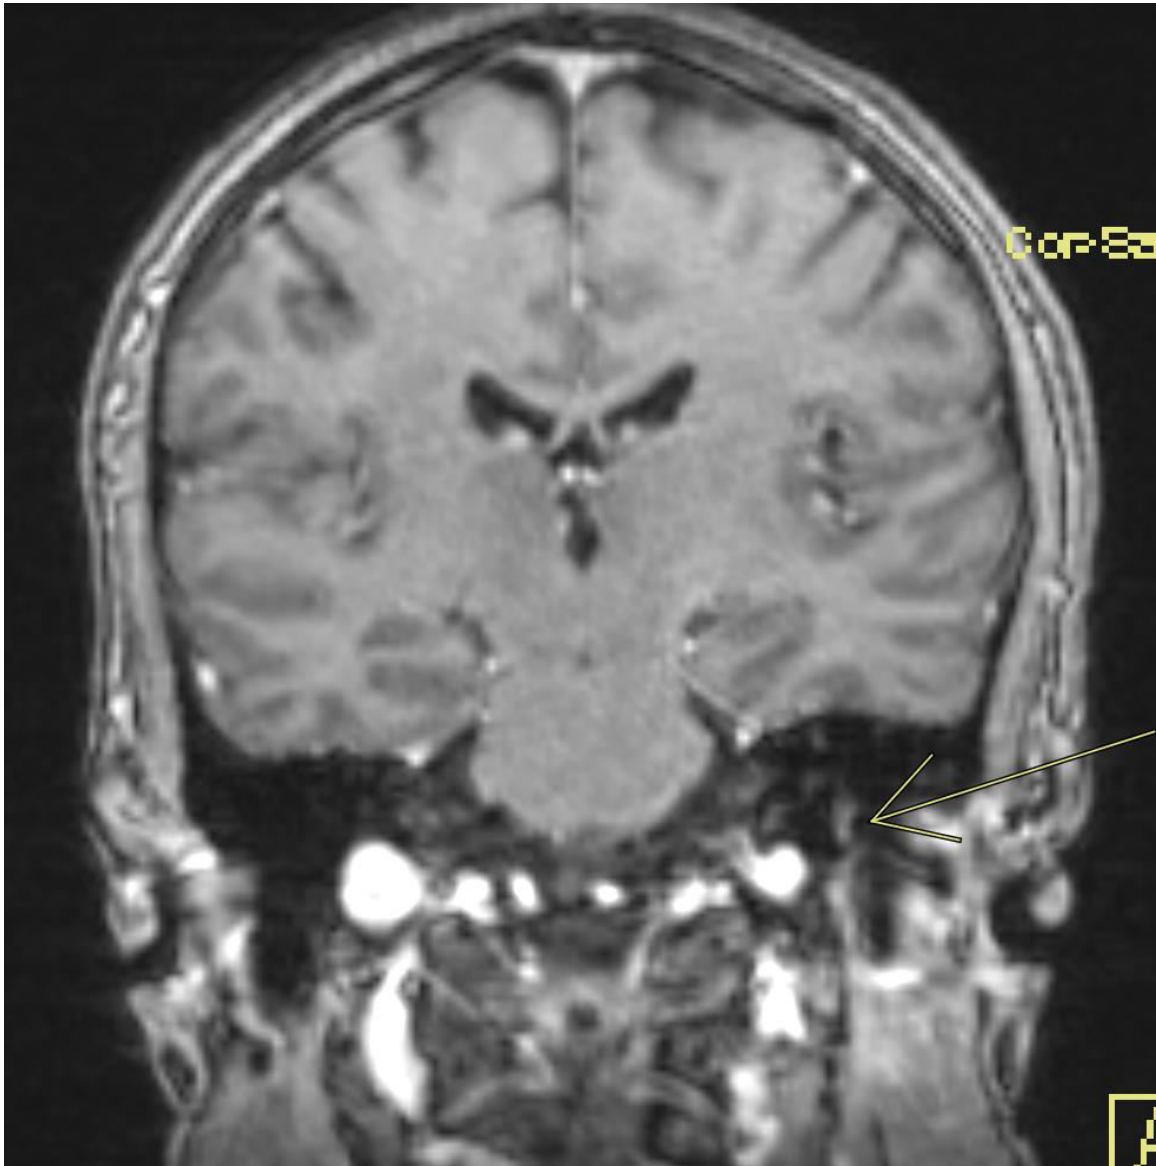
Brain MRI with IV contrast showed a subtle enhancement at the facial nerve at the initial presentation
